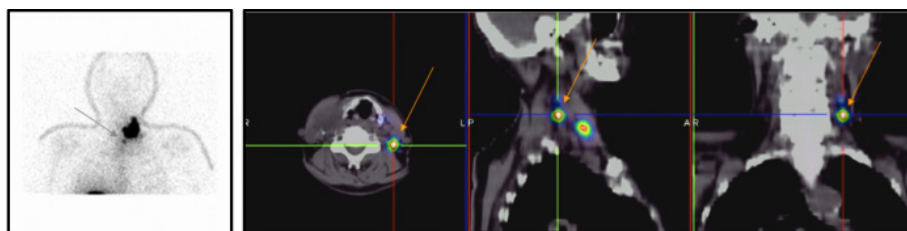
SLNM in a 71 year old woman with papillary carcinoma of the left thyroid lobe. Left: Anterior planar view obtained 2 h after US guided intratumoural injection of  $^{99m}\text{Tc}$  nanocolloid. The injection site corresponds to the area with greatest radioactivity accumulation in the left cervical region; only one LN is visualized, just below the thyroid approximately at the midline (grey arrow). Right: Fused SPECT/CT sections (transaxial, sagittal and coronal) selected so that they show part of the radioactivity accumulation at the injection site (visible in the sagittal section, not indicated by a specific mark) and a draining LN in level III (orange arrow); this second SLN had not been identified in the planar image because of the close proximity to the injection site. Images courtesy of L. Feggi and S. Panareo, Nuclear Medicine Service, University Hospital, Ferrara, Italy.
